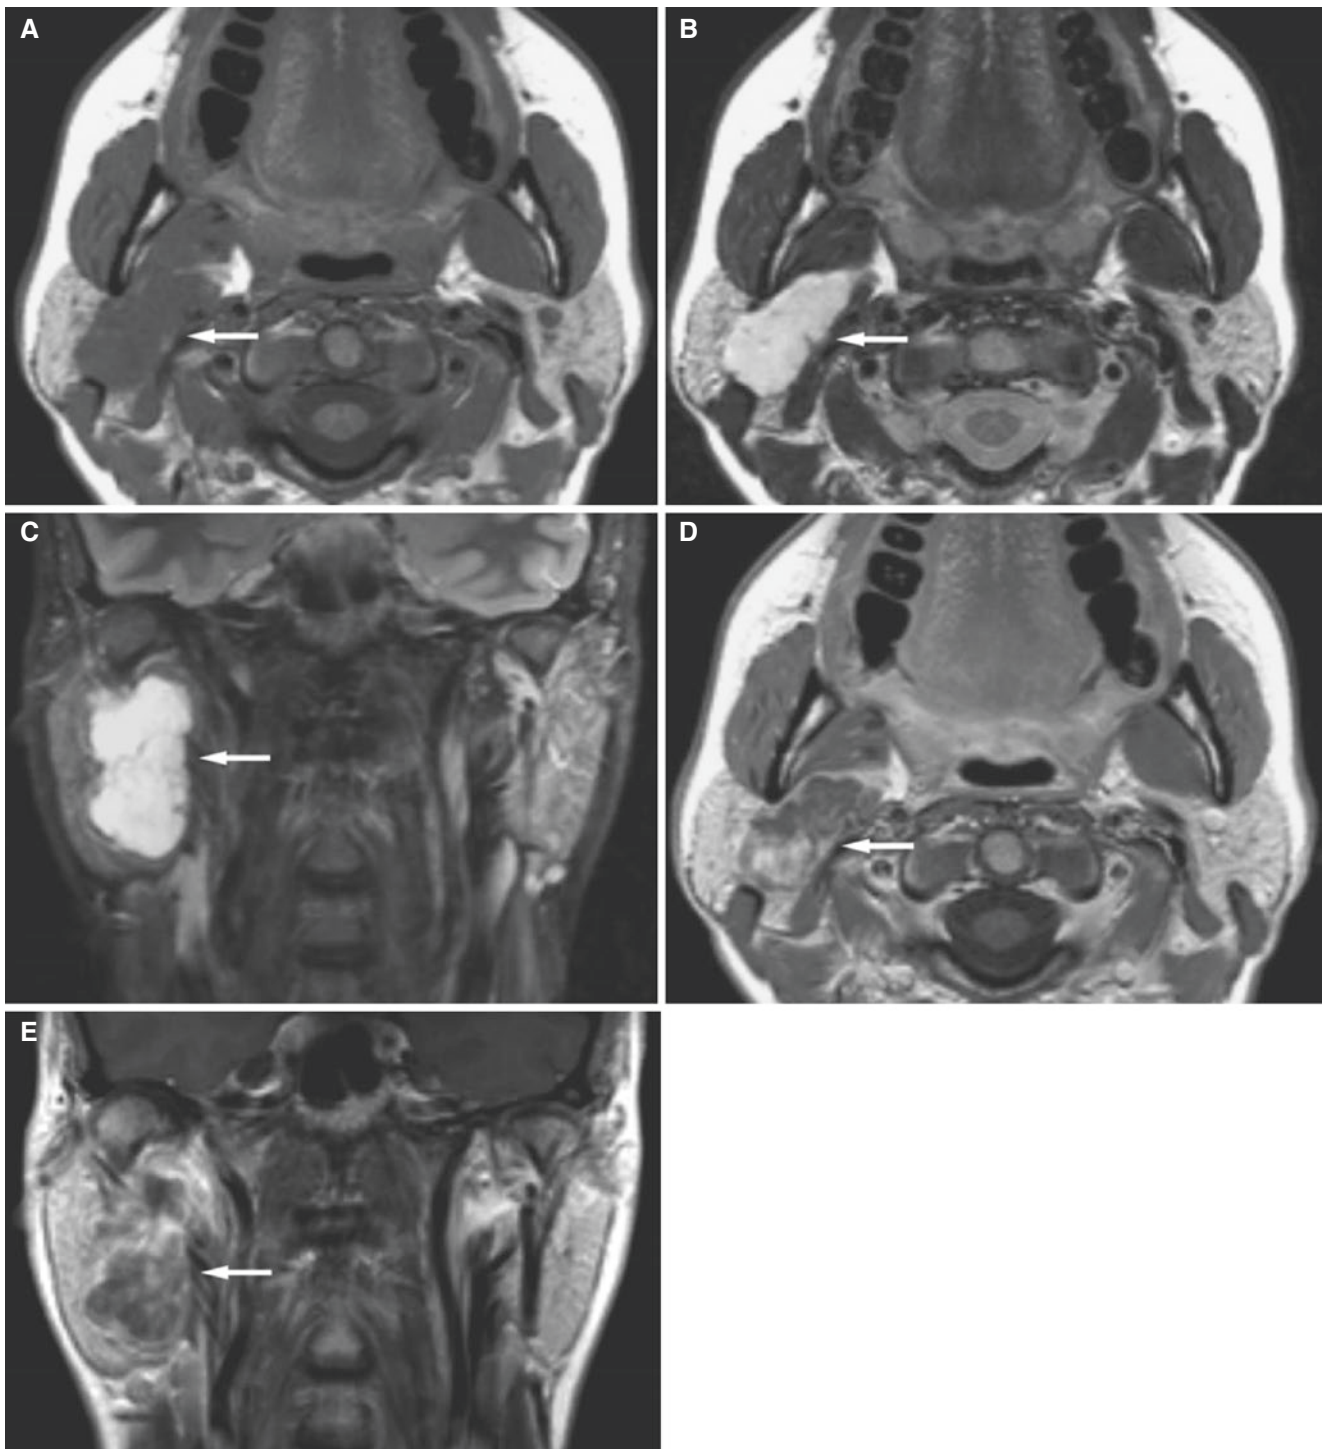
Parotid pleomorphic adenoma, deep lobe; 40-year-old female with swelling of the right parotid gland. (A) Axial T1-weighted MRI shows well-defined low-signal mass in deep lobe of the right parotid gland (*arrow*). (B) Axial T2-weighted MRI shows well-defined homogeneous high-signal mass (*arrow*). (C) Coronal STIR MRI shows
